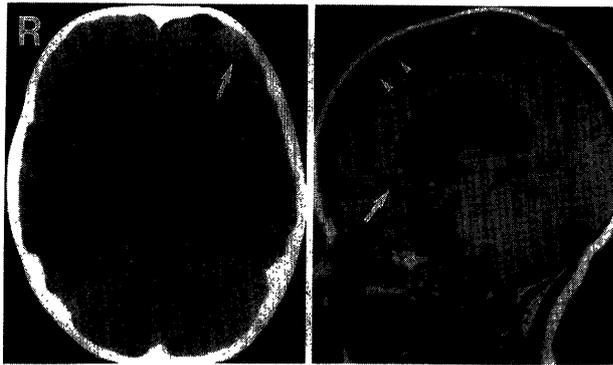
left*: Precontrast CT scan demonstrating ventricular enlargement and a mass in the left frontal subdural area (*arrow*). *right*: Sagittal T₁-weighted MR image demonstrating flow void signs in the left frontal area (*arrow*) indicating feeders of the vascular malformation, and dilation of the superior sagittal sinus (*arrowheads*).
